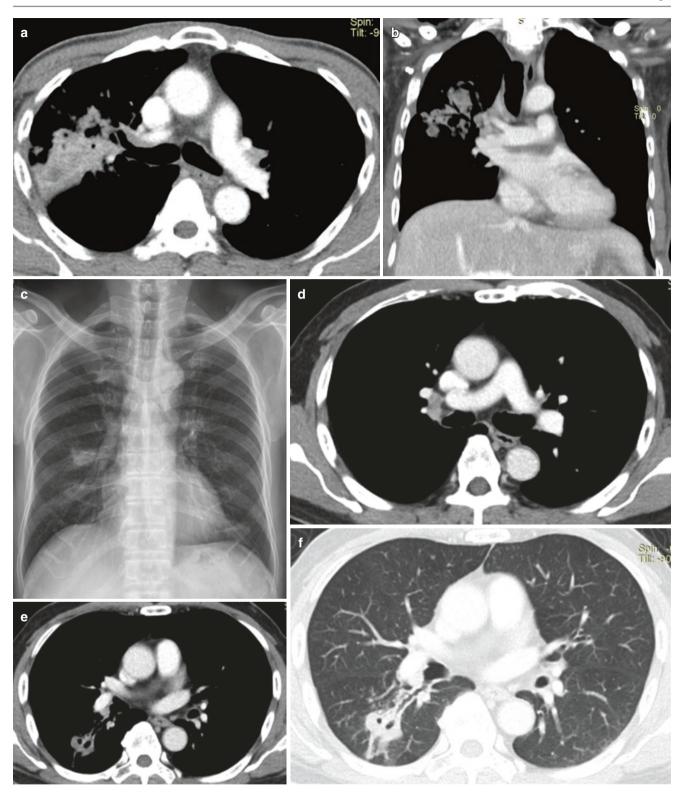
Primary tuberculosis in an adult. (a, b) Axial and coronal CT images show heterogeneous consolidation in the right upper lobe with hilar lymph nodes. Post-primary tuberculosis in another patient. (c) Frontal chest
